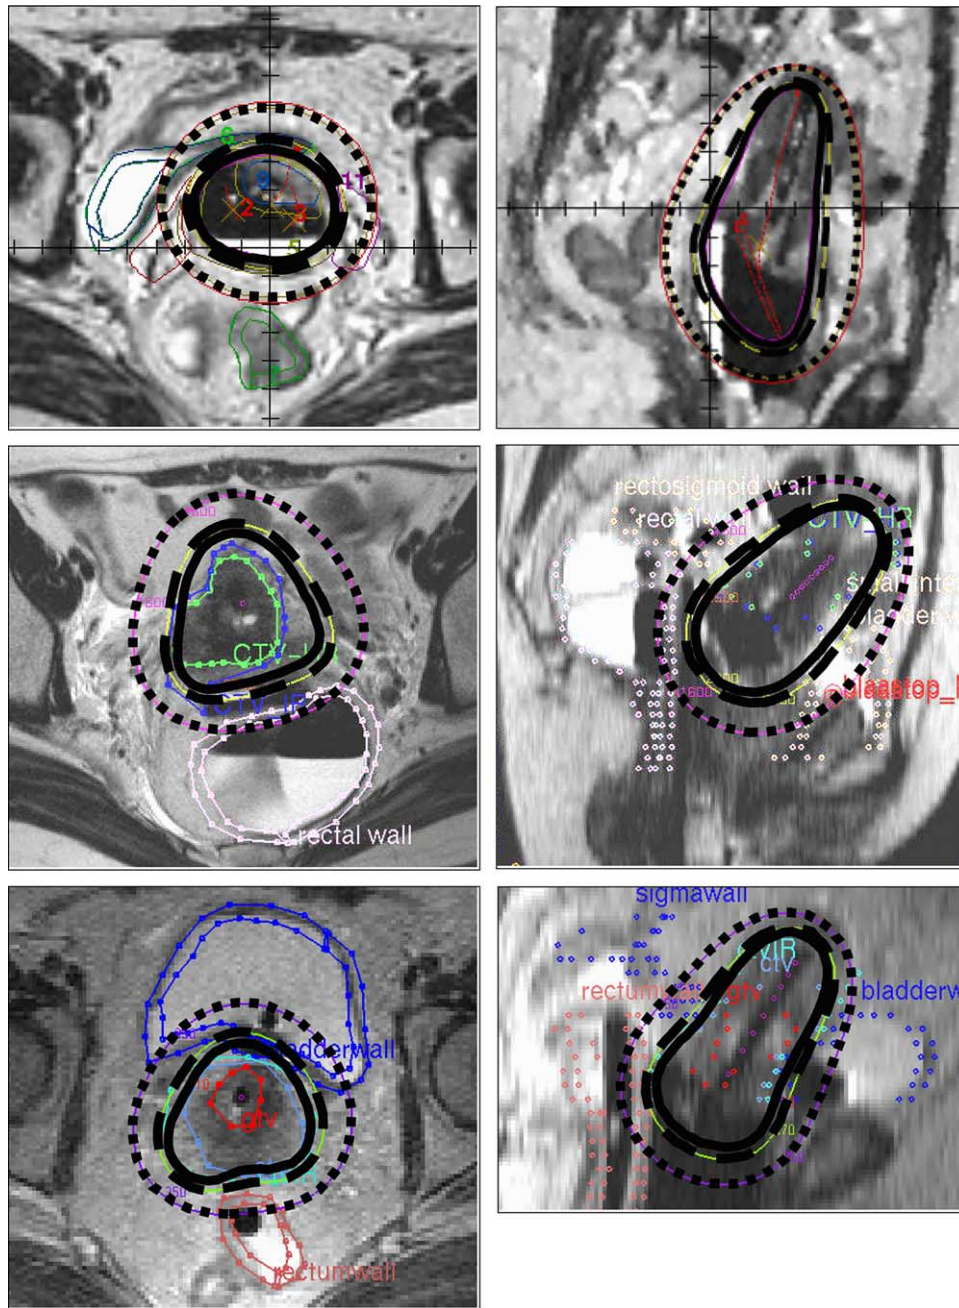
Axial and multiplanar reconstructed sagittal MRI sections for the three investigated patients from IGR Paris (top), University Hospital Leuven (middle) and Medical University of Vienna (bottom). Isodoses representing ICRU Report 38 reference volumes at biologically normalised EQD₂ dose levels of 60 Gy (dotted lines), 75 Gy (broken lines) and 85 Gy (solid lines) are indicated.
